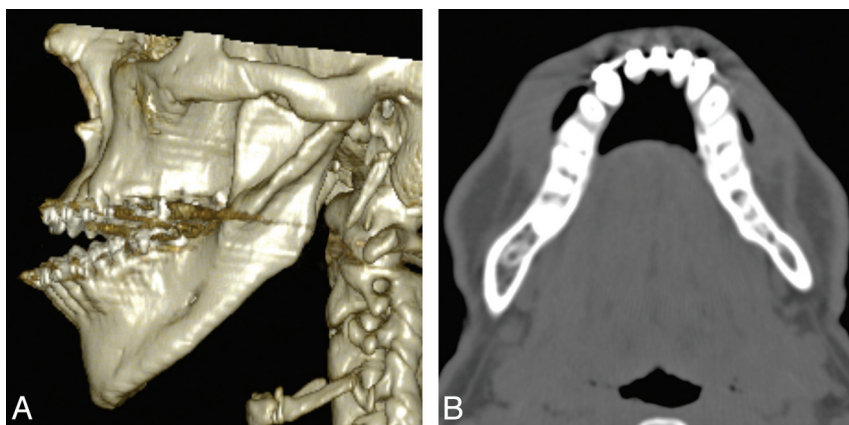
An 18-year-old man with ACS. *A*, 3D bony reconstruction shows micrognathia with overprotrusion of the mandible in relation to the maxilla. The lateral mandibular cleft is a feature commonly seen in ACS (see also Fig 2). *B*, Axial CT scan also shows the asymmetry of the dysplastic protruding mandible.
